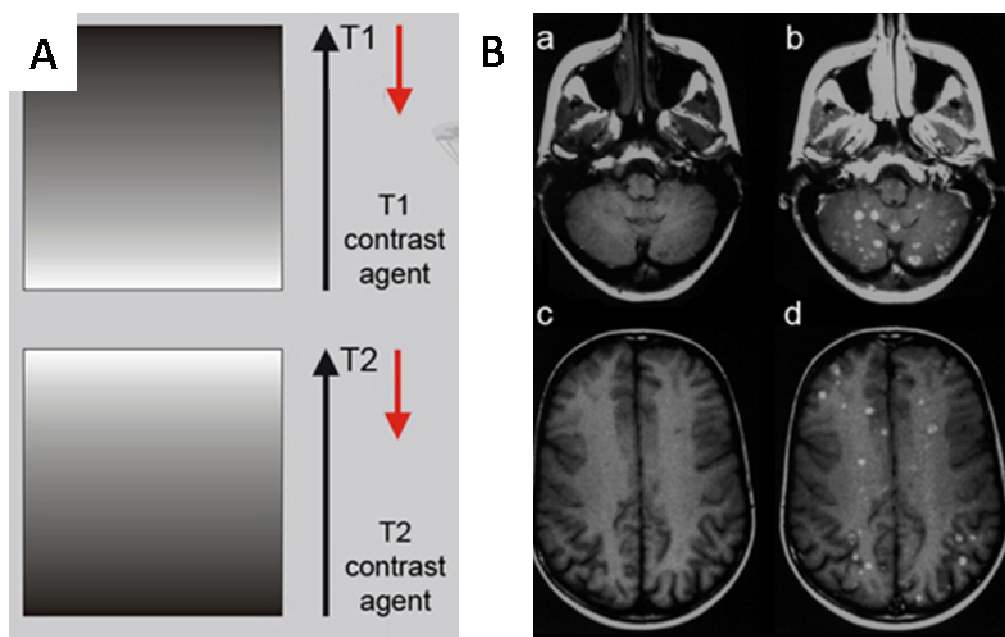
(A) Influence of positive (T_1) and negative (T_2) MR contrast agents upon signal intensity. (B) Example of a clinical case where only the application of a positive contrast agent helped the diagnostic process to show the extent of the disease (breast cancer and recent neurological symptoms). The plain MR T_1 -weighted images (pre-contrast a and c) do not reliably reveal brain lesions. However, the contrast-enhanced MR images (post-contrast b and d) show a large number of metastases.²³
